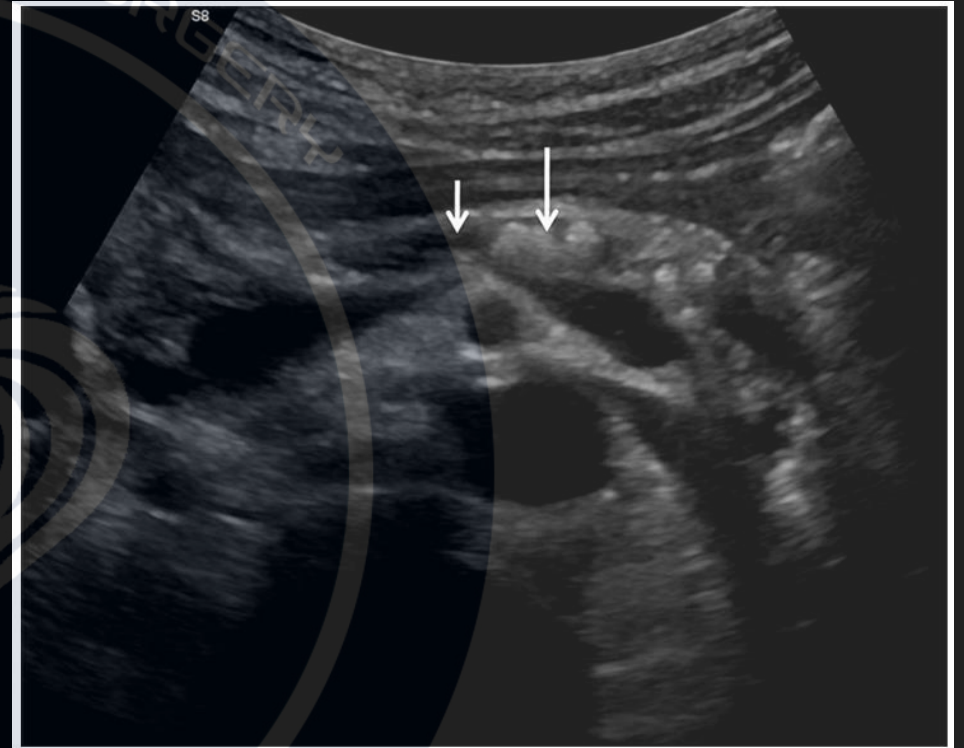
Abdominal ultrasound shows atrophic pancreas with dilated main pancreatic duct (short arrow) with intraductal calculi (arrow)
